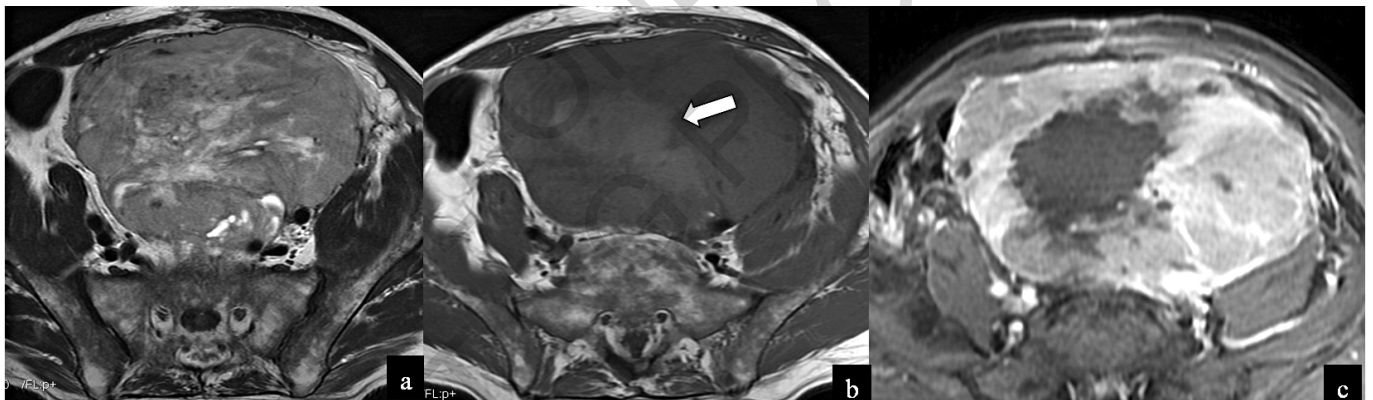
Pleomorphic liposarcoma. Axial T2-weighted (a), T1-weighted (b), and axial contrast enhanced fat saturation T1-weighted (c) MR images show a large well defined retroperitoneal heterogeneous soft-tissue mass, with central areas of hemorrhage (arrow).
